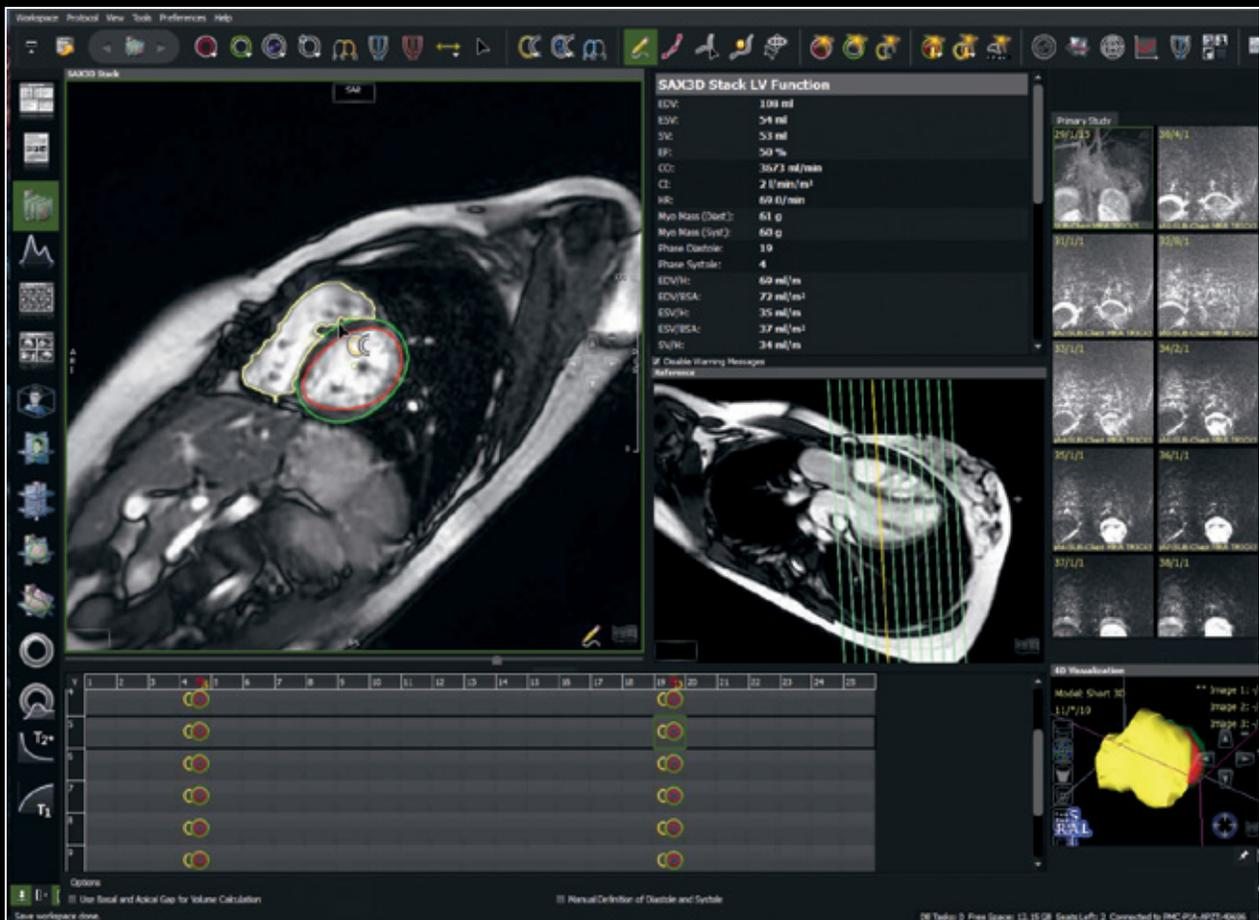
Patient with Tetralogy of Fallot: (A) Using a volumetric short axis cardiac MR image, the clinician can draw the contours of the end-diastolic and end-systolic phases.
